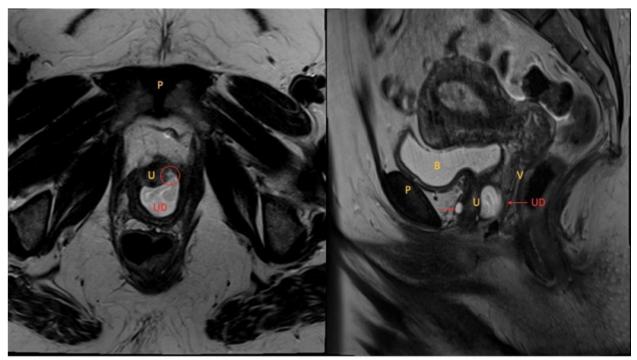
Complex urethral diverticulum with ostia (circled) noted on T2-weighted contrast enhanced MRI. *U*, urethra. *B*, bladder. *P*, pubic bone. *V*, vagina.
